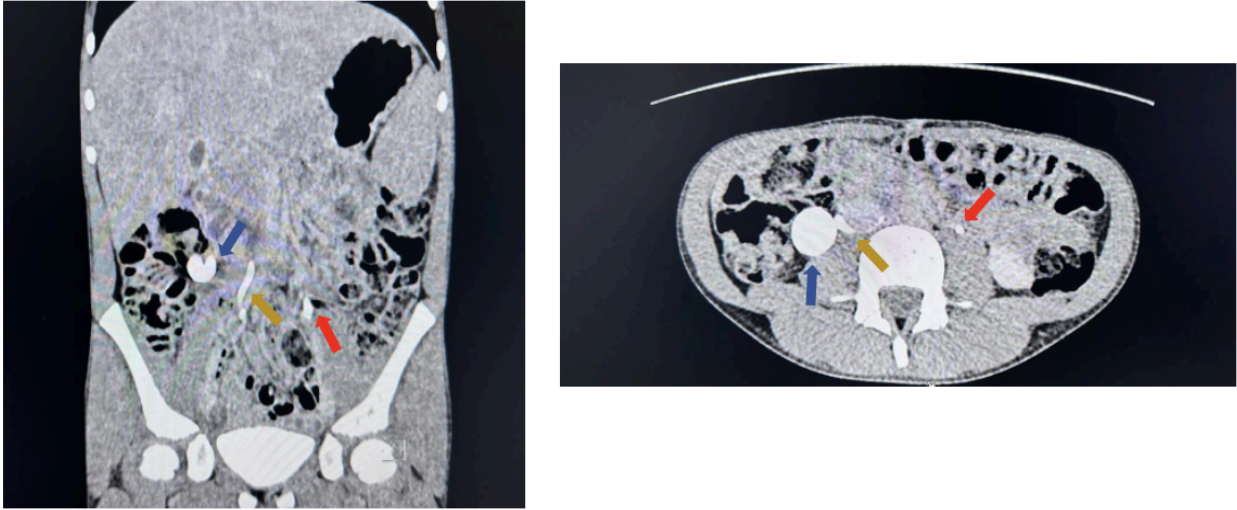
CT urography demonstrating right-sided hydronephrosis (blue arrow) and medial deviation of the proximal right ureter as it courses posterior to the IVC with a normal-caliber distal ureter (yellow arrow). The left ureter appears normal in both course and diameter (red arrow).
